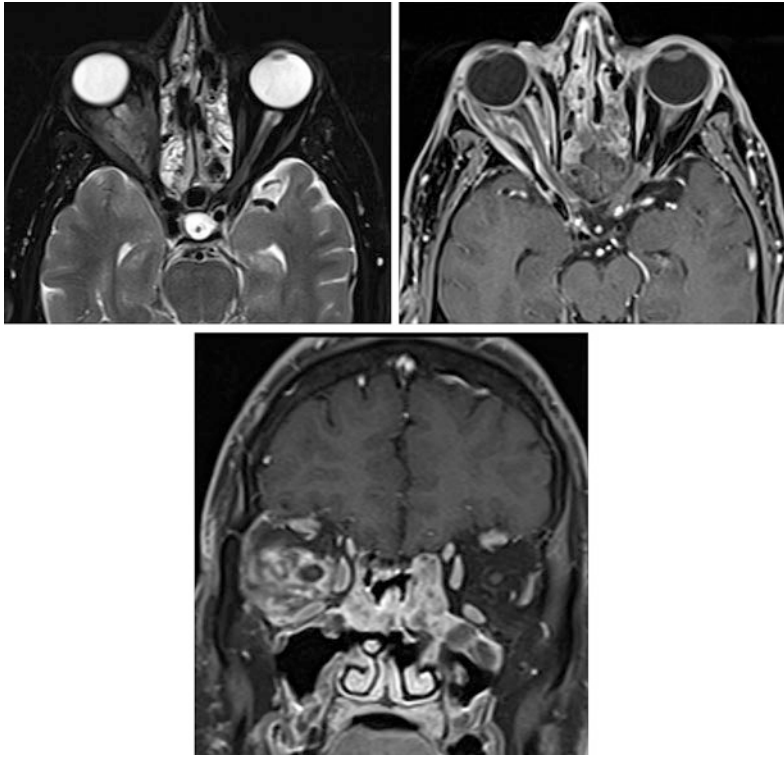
A-65 years old female patient with right orbital lymphoma. a-c Axial T2WI, axial and coronal T1WI with fat suppression MR images demonstrate enhancing right orbital intraconal infiltrative soft tissue mass extending along the optic nerve. The mass has instead of shows low T2 signal and intense homogenous enhancement showing tram track/target sign
